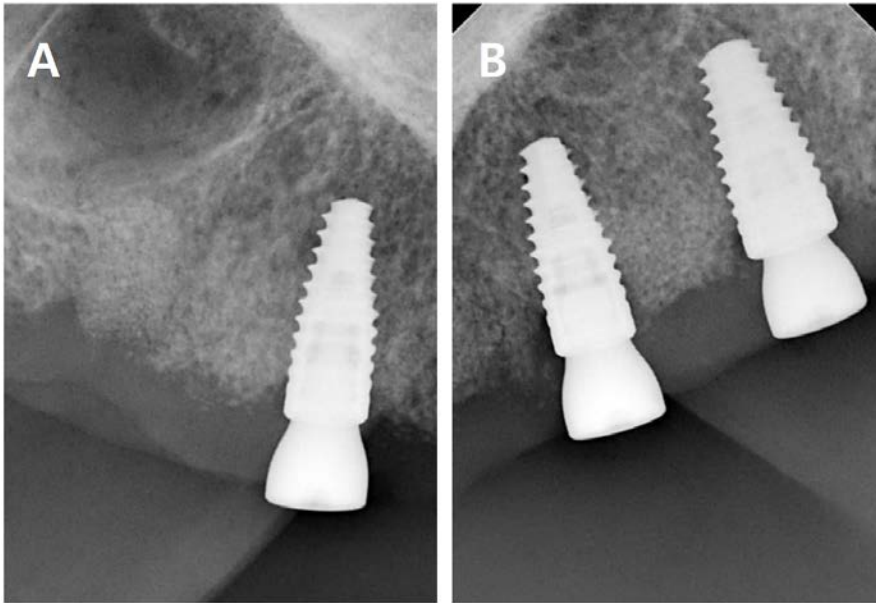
Periapical radiograph at 13 weeks later of implant surgery. (A) #13 implant. (B) #23, 25 implant.
